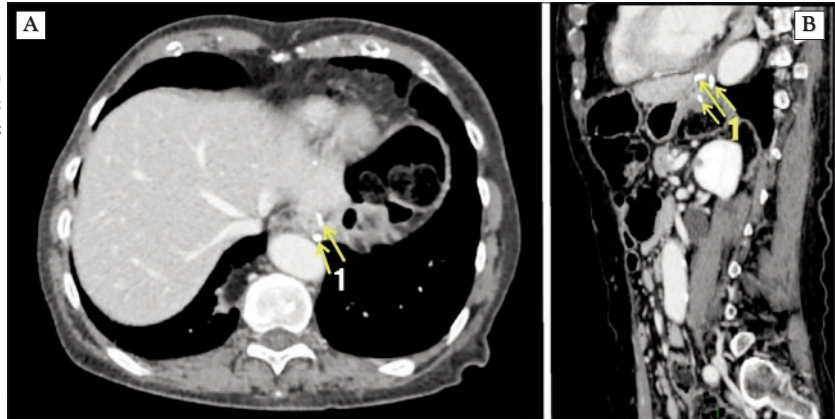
Postoperative contrast-enhanced computed tomography following surgical repair of an incarcerated hiatal hernia. (A) Axial and (B) sagittal views demonstrating the esophagogastric anastomosis. Arrows (1) indicate the anastomotic staple line.
